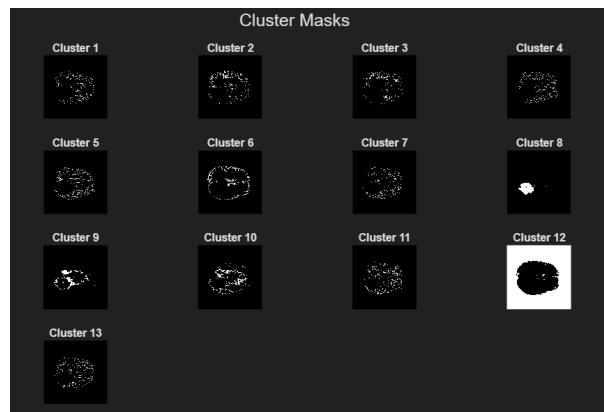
13 Clusters extracted from brain MRI
